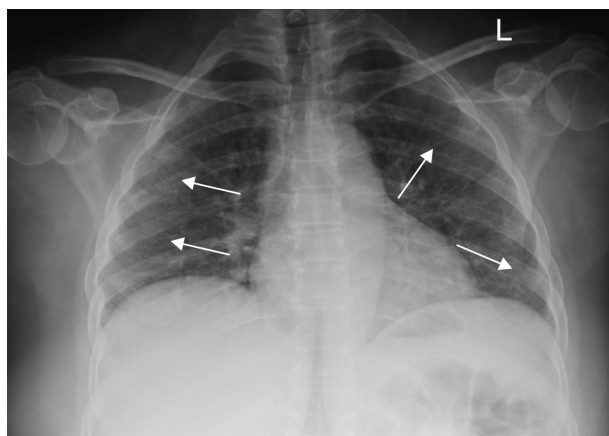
Postero-anterior chest X-RAY in one asymptomatic patient with coronavirus disease 2019 pneumonia from our institution. It shows Interstitial infiltrates and ill-defined, patchy, peripheral opacities in bilateral lung fields.
